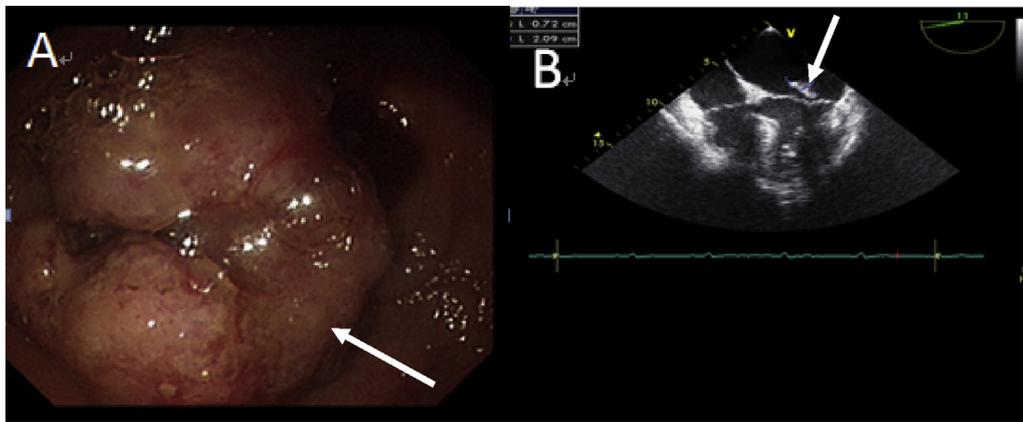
(A) The colonoscopy revealed a huge fungating mass (white arrowhead) at the descending colon (B) The transesophageal echocardiography (TEE) showed a 2 cm in diameter vegetation (white arrowhead) on the mitral valve leaflet.
